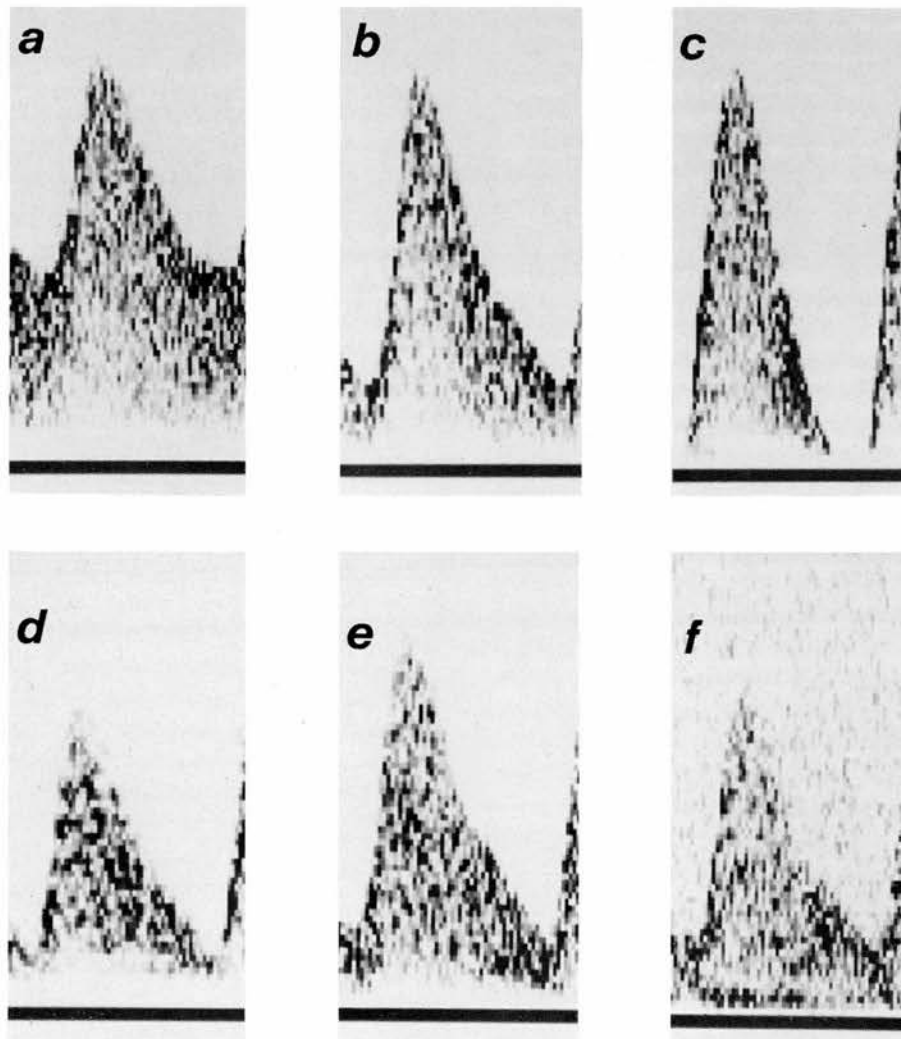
Doppler waveforms used for filter development. Values of physical parameters associated with each waveform are given in the table below:
